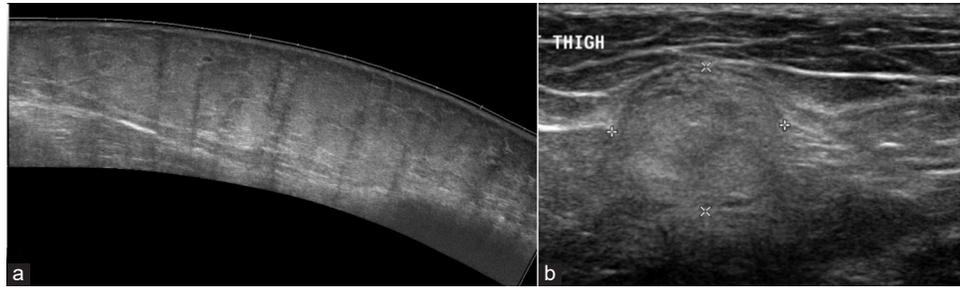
(a) Panoramic image of the lower leg demonstrating a superficial subcutaneous fatty lesion, which is isoechoic to the surrounding fat and is compressible. No aggressive imaging features demonstrated in keeping with a superficial lipoma. (b) Transverse ultrasound image of an intramuscular lesion which is echogenic typical for an intramuscular lipoma. Due to its location, an magnetic resonance imaging should be performed to characterize it.
